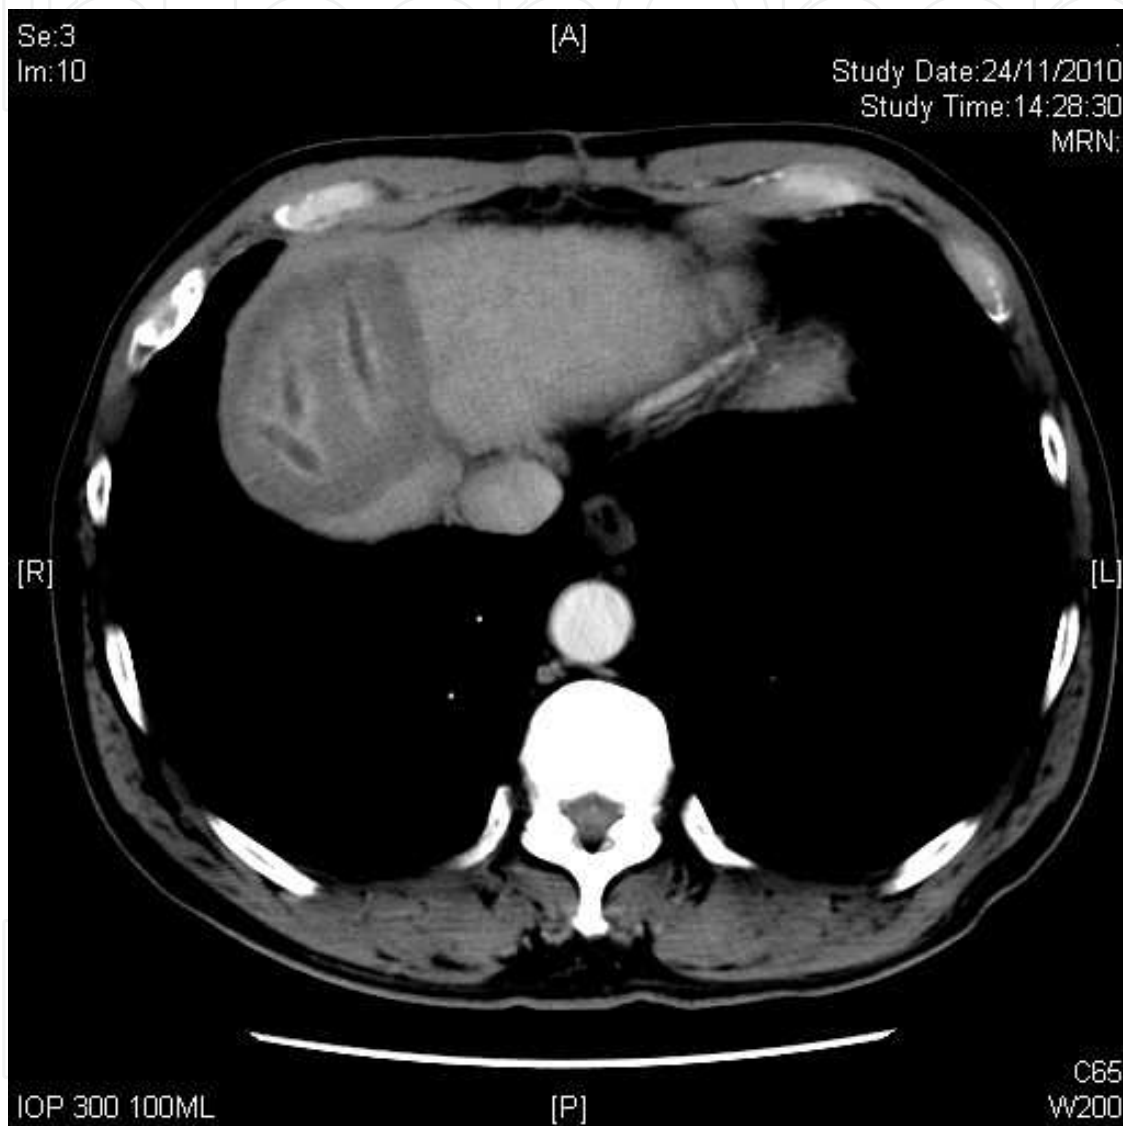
CT image of a patient with a 5cm segment VIII recurrent HCC at 6 months after microwave ablation. Three passes were performed for a bigger ablative zone and the needle tracts were showed on the follow up scan.
